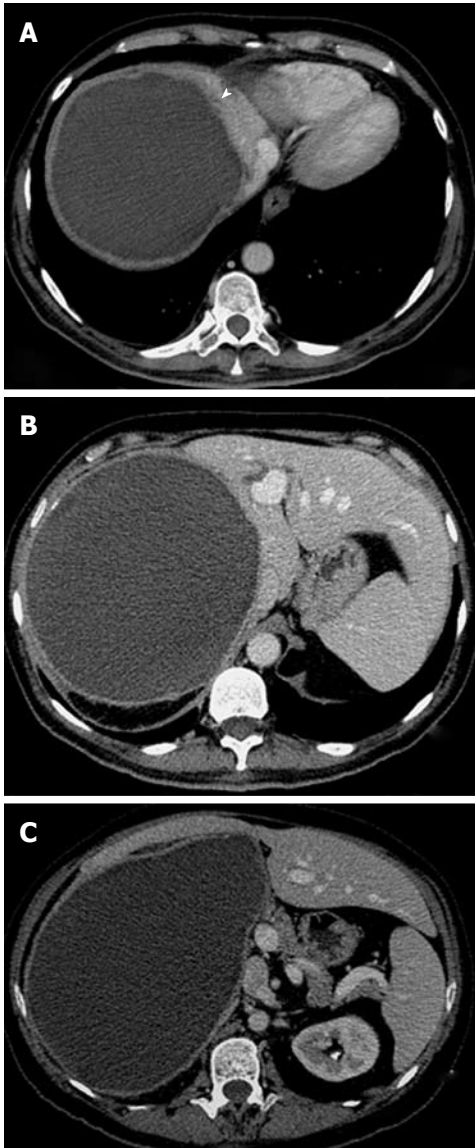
Computed tomography scan shows a huge nonenhancing mass with regular contours and thickened wall representing the pericyst (the white arrowhead) occupying all the right lobe of the liver (type I); either the right portal vein or the right hepatic vein is completely replaced.
